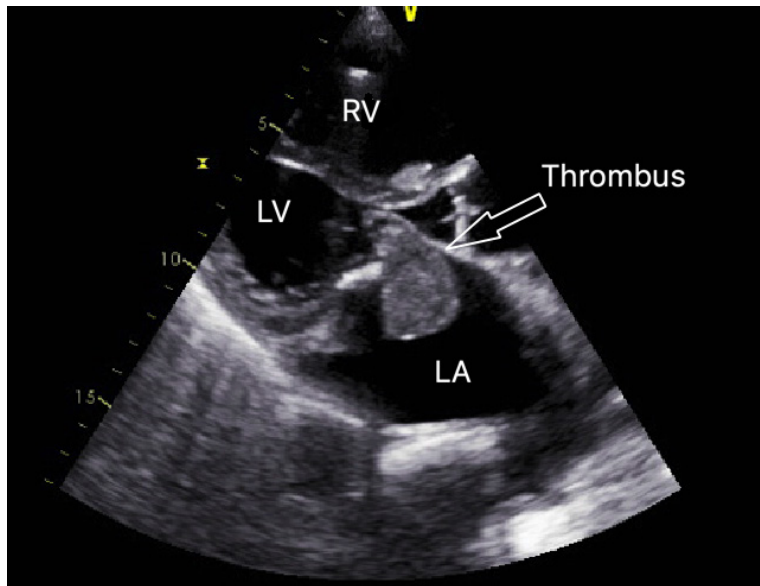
Transthoracic echocardiography showing an ovoid-shaped 3.5 x 2.8 cm echodensity, representing the thrombus. The thrombus is occluding mitral outflow in diastole.
